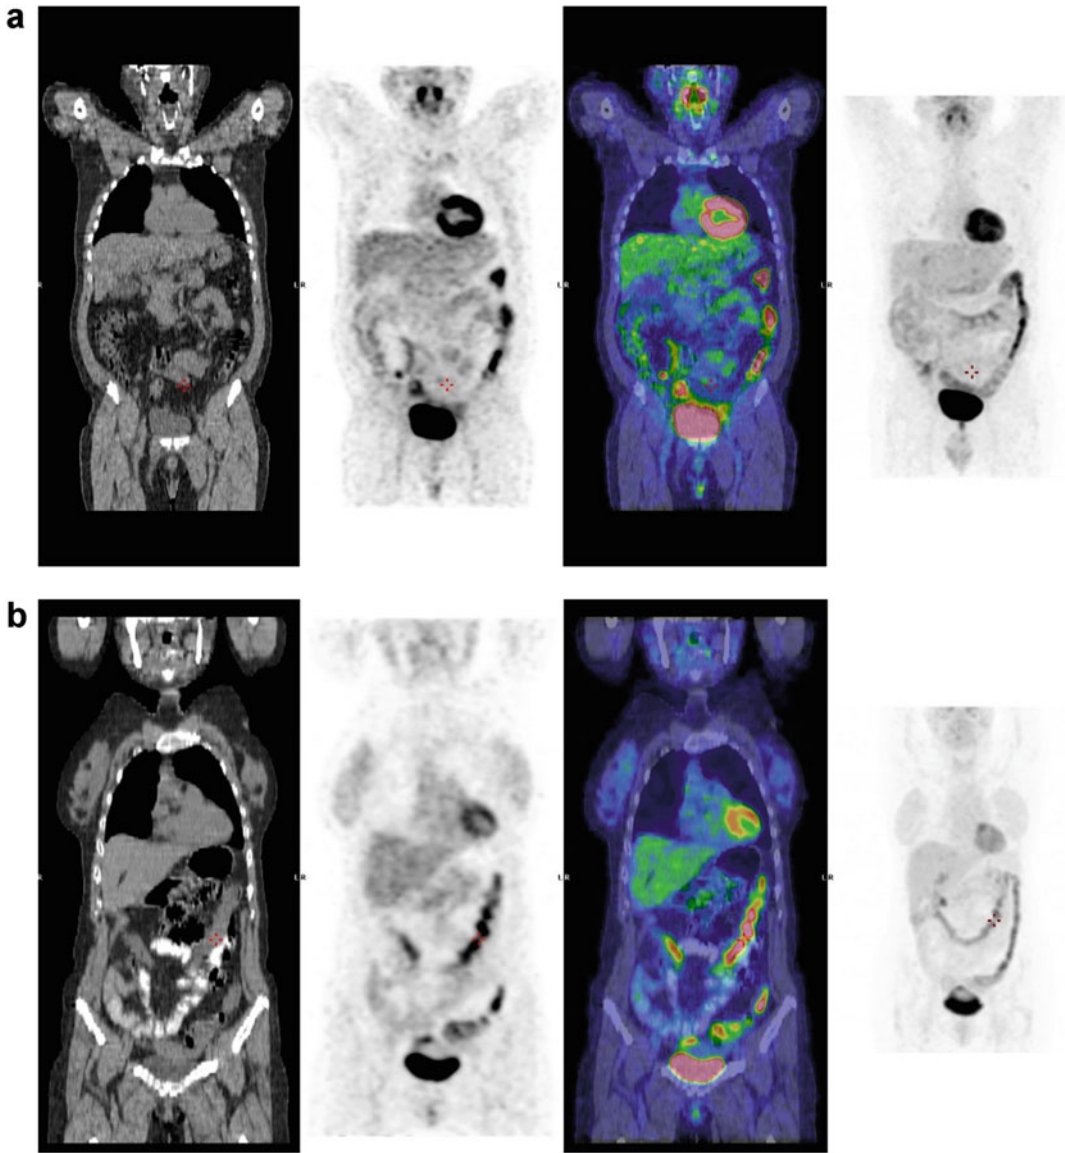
(a) [18F]FDG PET/CT scan performed for characterization of a hepatic lesion in a 41 year old diabetic patient treated with metformin. High intestinal uptake is visible in particular in descending colon. (b) [18F]FDG PET/CT scan performed for suspected occult
